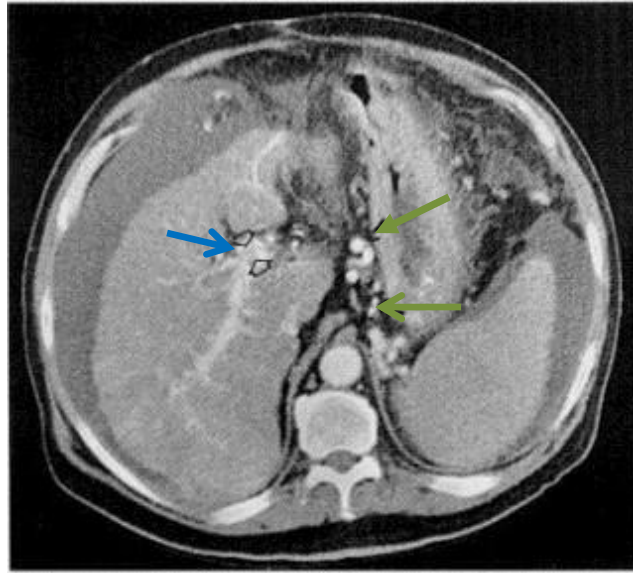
Enhanced CT scan shows a lobulated contour of the liver, splenomegaly, portosystemic collaterals (red arrows), and ascites. There are enlarged hepatic arterial collateral vessels and thrombus within the portal vein (blue arrows)
